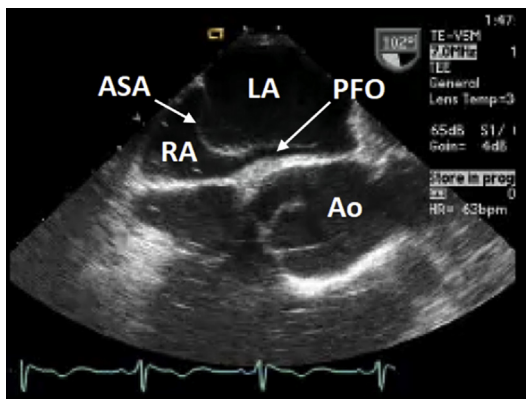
Transesophageal echocardiography showing a long-tunnel PFO with an atrial septal aneurysm (ASA). Ao, aorta; LA, left atrium; RA, right atrium.
